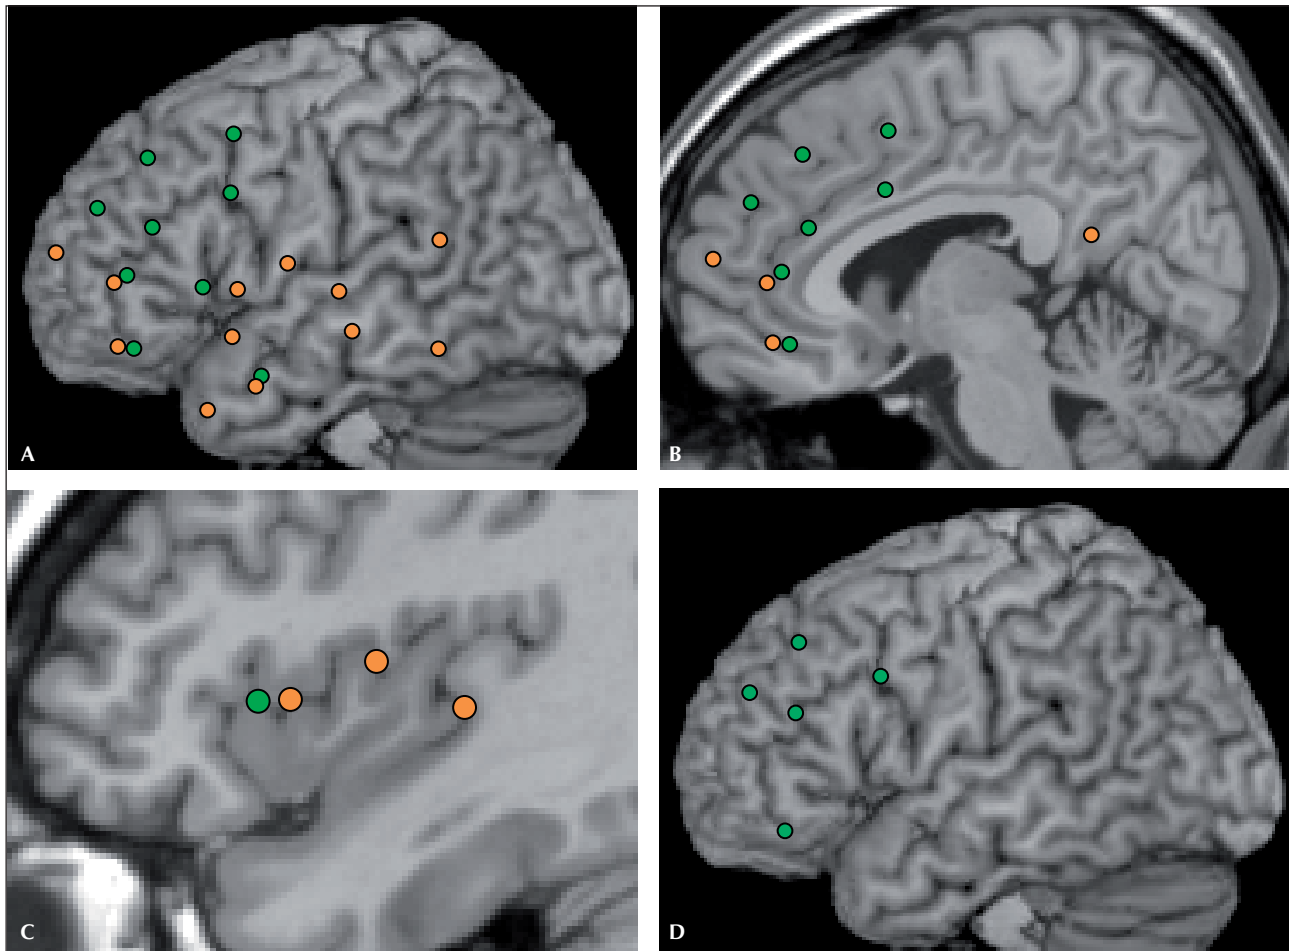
Electrode location of patient 1 (orange) and 2 (green) co-registered on a normal subject, sagittal T1 MRI. A) Lateral sagittal view of electrodes implanted ipsilateral to the seizure-onset zone (right hemisphere for patient 1 and left hemisphere for patient 2). Arrows indicate electrodes targeting the insula; B) Mesial sagittal view of electrodes implanted ipsilateral to the seizure-onset zone. C) Intermediate sagittal view of the electrodes targeting the insula, ipsilateral to seizure-onset; D) Lateral sagittal view of electrodes implanted contralateral to the seizure-onset zone (right hemisphere in patient 2).
